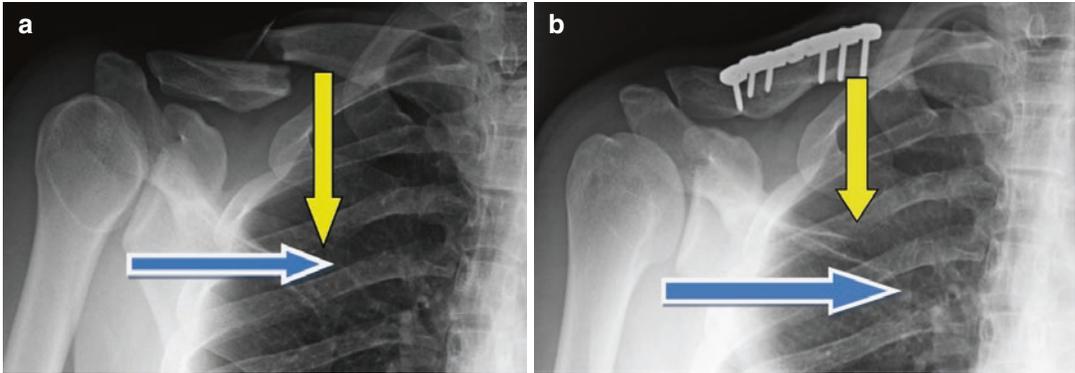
(a, b) With fracture, a resulting protracted scapula, may yield a relatively narrower scapula width on AP radiographs compared to postreduction *blue arrows* , as well as a greater medial fragment inferior
